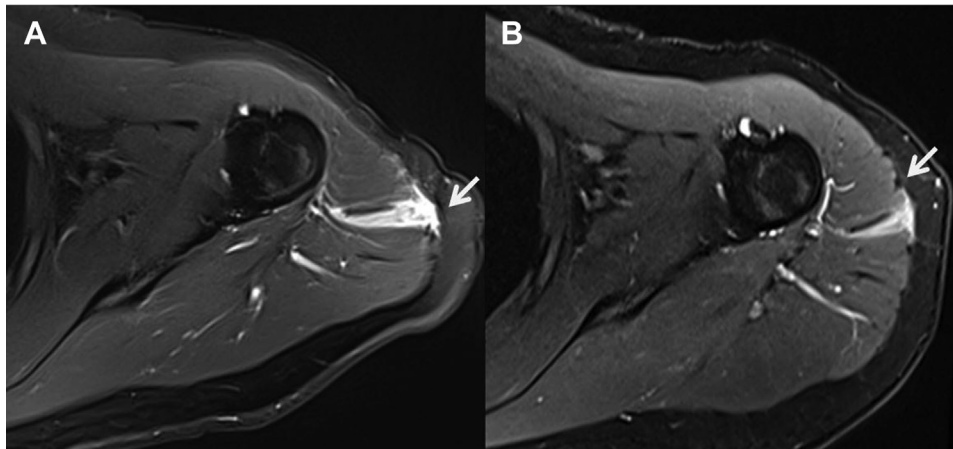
Case 2. (A) High signal intensity can be observed along the fascia and muscle of the middle part of the deltoid on the T2-weighted image. (B) After one month, the previously seen high signal intensity had decreased on the T2-weighted image.
